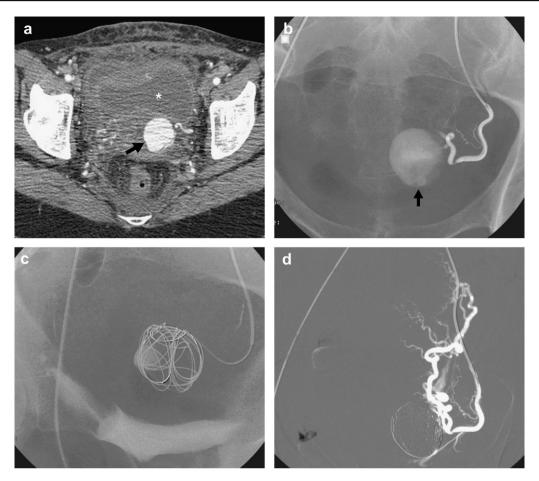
Patient 15: A 32-year-old woman presented to the emergency department with fever and pelvic pain 10 days after caesarean delivery. (a) Pelvic post-contrast axial multi-slice spiral computed tomography (CT): pelvic mass that shows contrast filling at the arterial phase (*arrow*) with an anterior collected hematoma (*asterisk*). (b) Selective left uterine arteriogram showing filling of a pseudoaneurysm (PA) (*arrow*) arising from the uterine artery pedicle. (c) Coil embolisation of the aneurysmal sac across the neck using the three-dimensional packing technique through a microcatheter. (d) Control angiography showing complete occlusion of the PA and preservation of the main and distal uterine artery.
